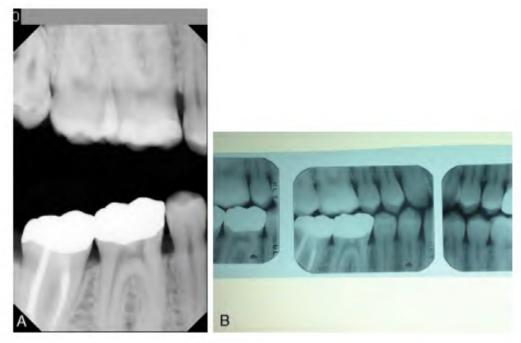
(a) A postmortem bitewing radiograph. (b) A set of antemortem bitewing radiographs.
